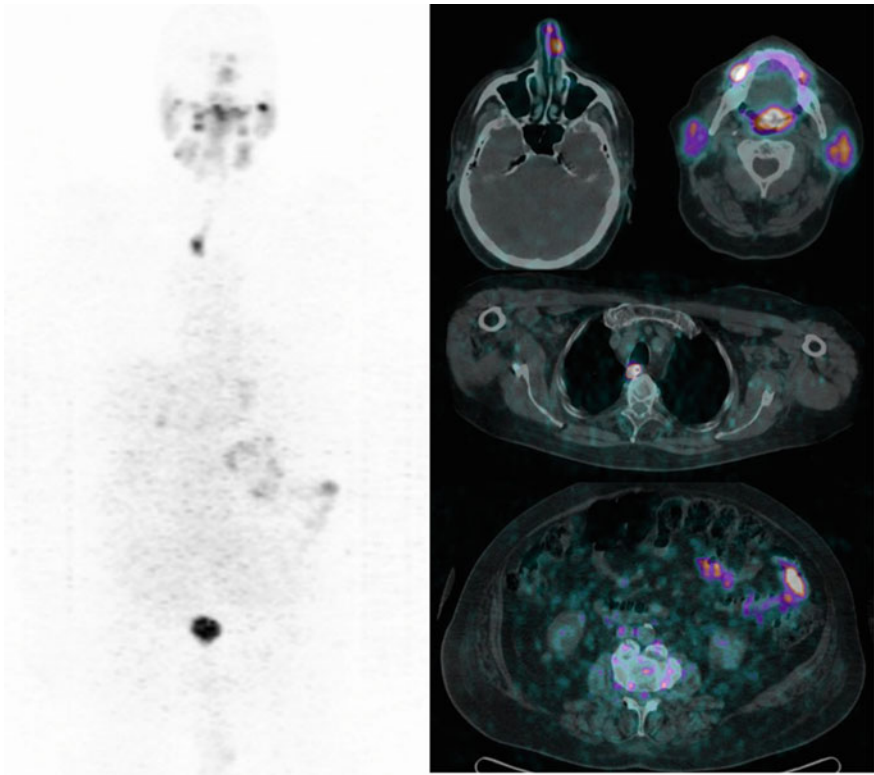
MIP image of ^{124}I -Iodine PET/CT (left-sided panel of the figure), with axial images of a patient referred for suspicious thyroid cancer relapse; the scan is negative for metastases, but shows multiple findings related to unspecific iodine accumulations; from top to bottom: nasal, salivary, buccal, esophageal and in intestinal uptake
